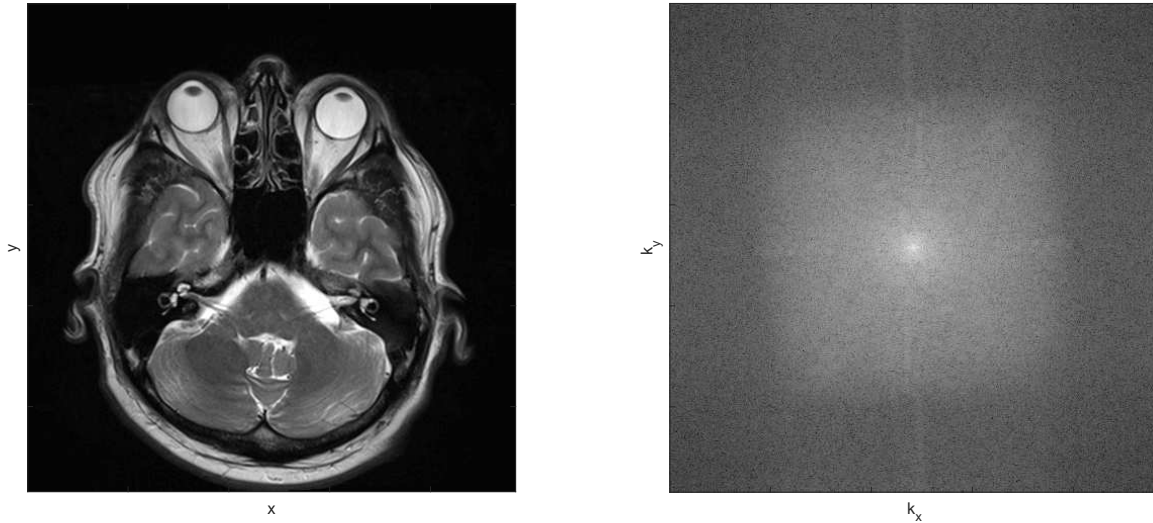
The k-space-reconstruction pair: left) An MRI k-space is a collection of MR samples in Fourier domain from different phase and frequency encoding positions; right panels shows a reconstructed MRI image from the k-space on the left panel.
